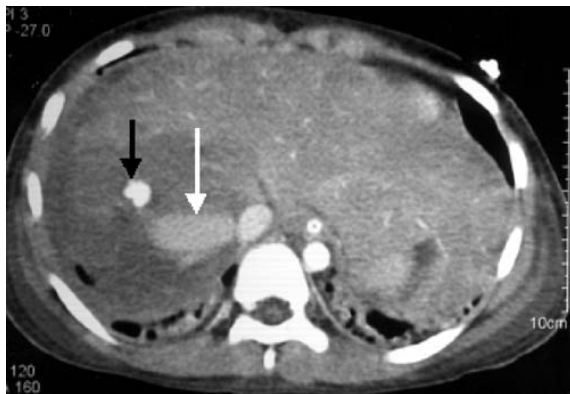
Contrast enhanced CT demonstrates two pseudoaneurysms in right lobe of liver (black and white arrows)
